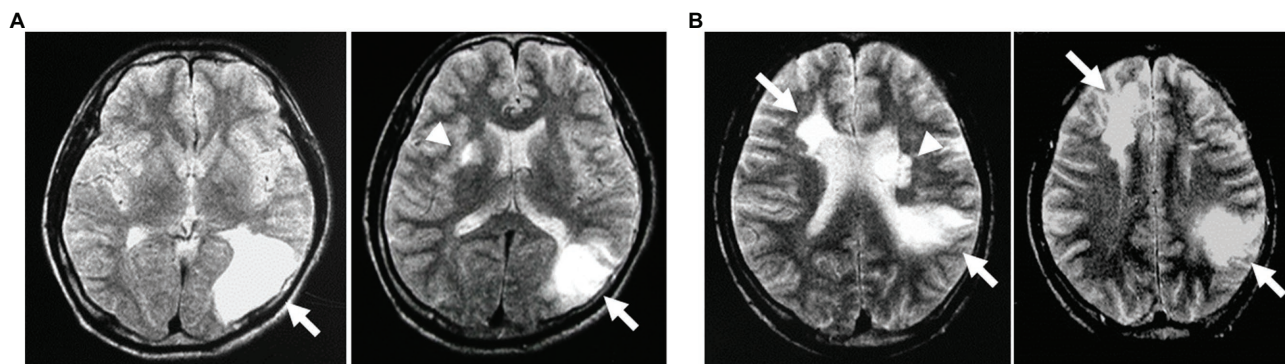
MRI of the brain in a 33-year-old assisted Ama diver with right homonymous hemianopsia. T2-weighted MRI obtained on the 4th day after the diving event shows two increased signal intensities in the left occipital lobe (arrow) and the right basal ganglia (arrow head; A). A 39-year-old assisted male Ama diver with right-sided hemiparesis and hemisensory numbness. He suffered from transient left hemiparesis at the age of 17, 25, and 27 years, and his T2-weighted MRI on the 3rd day after the event shows three increased signal intensities in the right frontal lobe and left parietal lobe (arrows) and the left basal ganglia (arrow head; B; taken from Kohshi et al., 2000 with permission).
